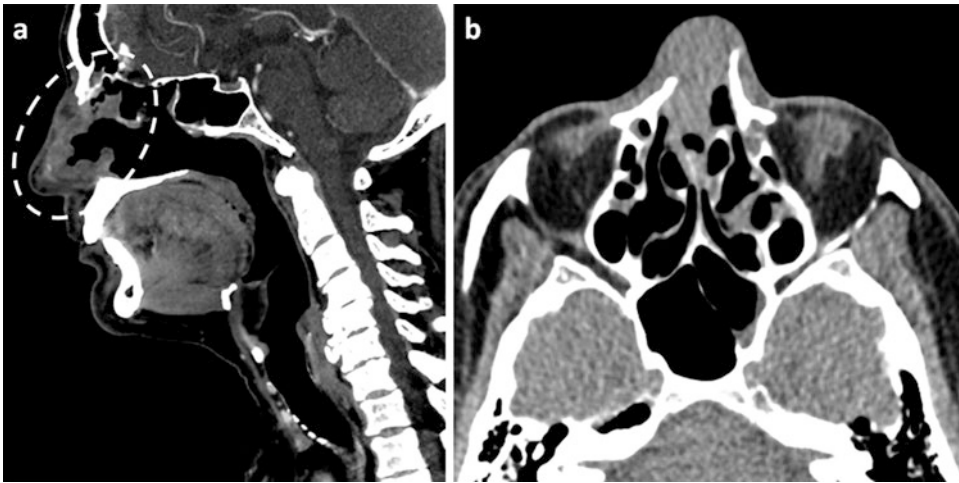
T2N2M0 sinonasal carcinoma. On CT there is a lobular irregular enhancing mass occupying most of the dorsa of the external nose with sparing of the nasal tip (a) and extending into and partially destroying the anterior aspect of the nasal septum (b). The mass measures up to 47 mm superoinferior \times 38 mm anteroposterior \times 22 mm transverse. Anteriorly it extends into the skin over the nasal
